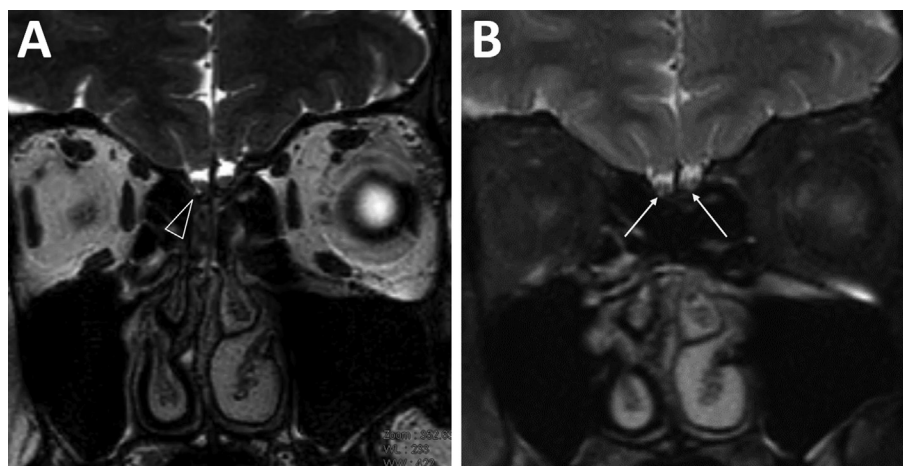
Magnetic resonance imaging of brain at 28 days after the onset of anosmia as the manifestation of COVID-19. The coronal 3D turbo spin echo image disclosed smaller right olfactory bulb (1A, hallow white arrowhead) and coronal 1 mm slice thickness T2-weighted MRI image with fat suppression revealed linear hyperintensities inside bilateral olfactory nerves (1B, white arrows), indicative of bilateral olfactory neuropathy.
